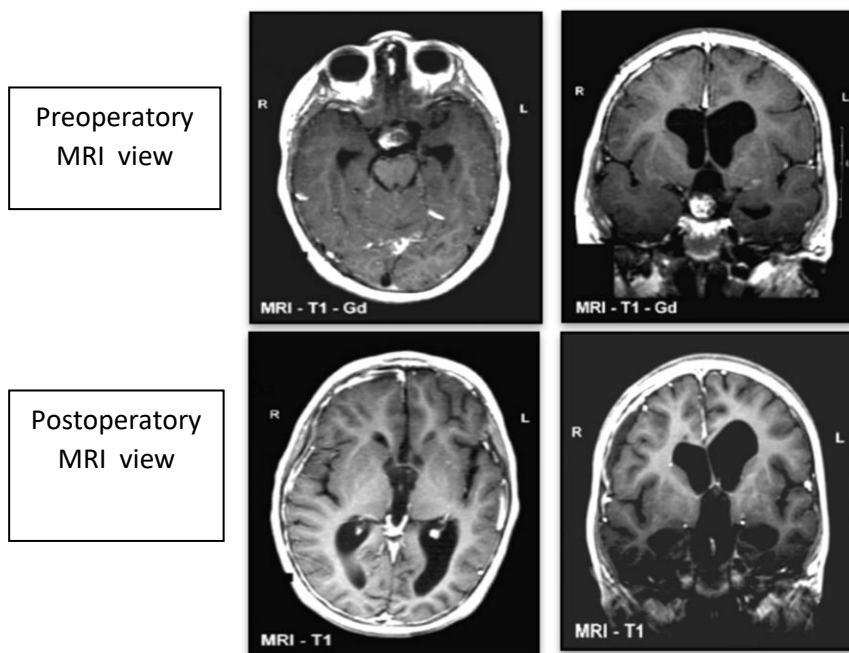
MRI presenting CP in male patient, no endocrine deficit, visual impairment. Treatment of choice total resection. Postoperative status has been improved.
